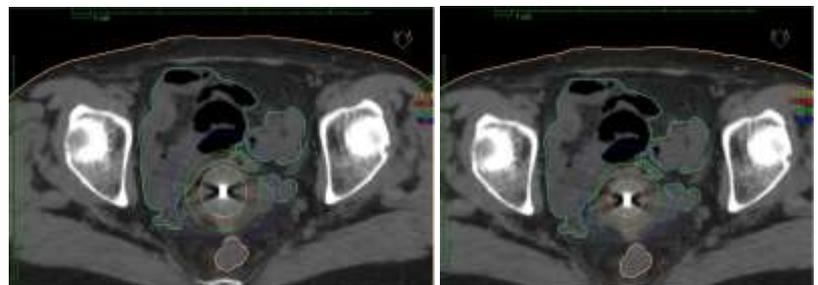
CT Image Guided Brachytherapy
